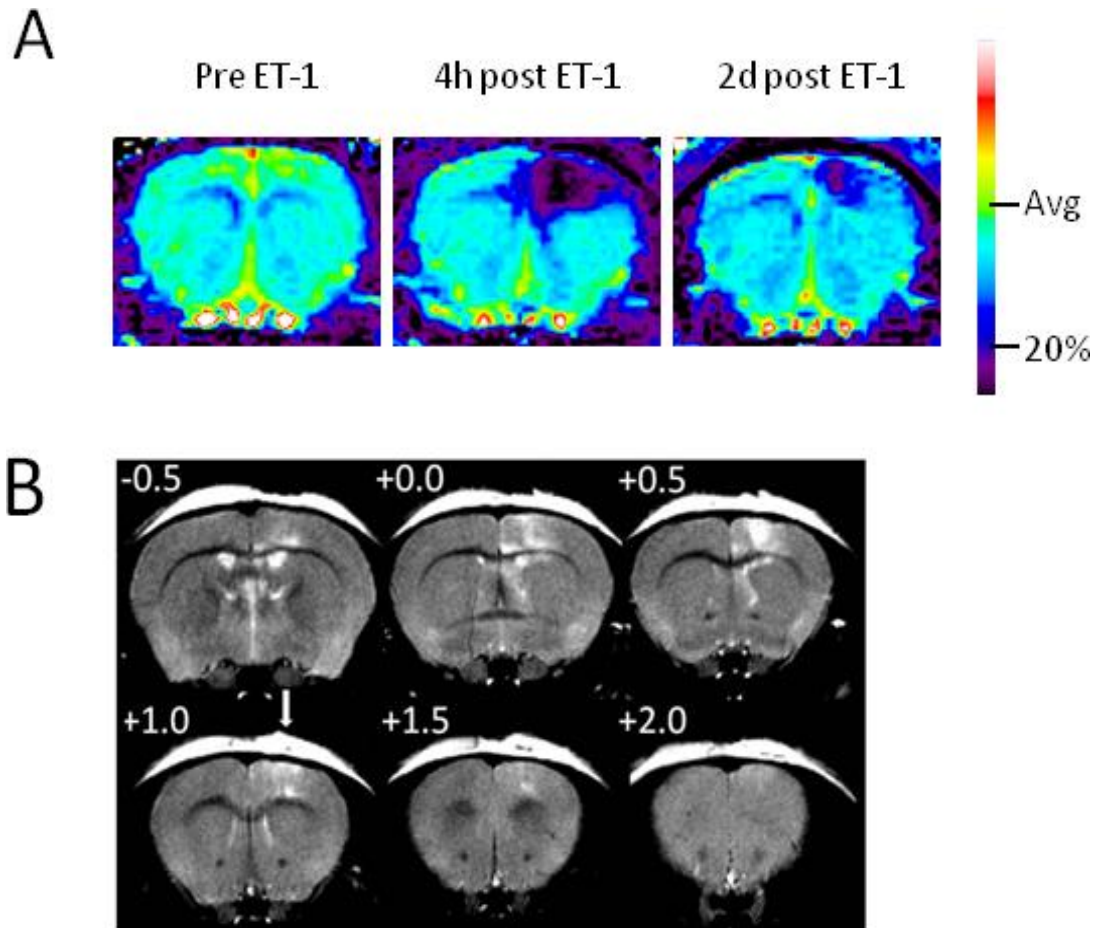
Perfusion weighted and T2 weighted MR images after IC injection of 1 μ l ET-1.
